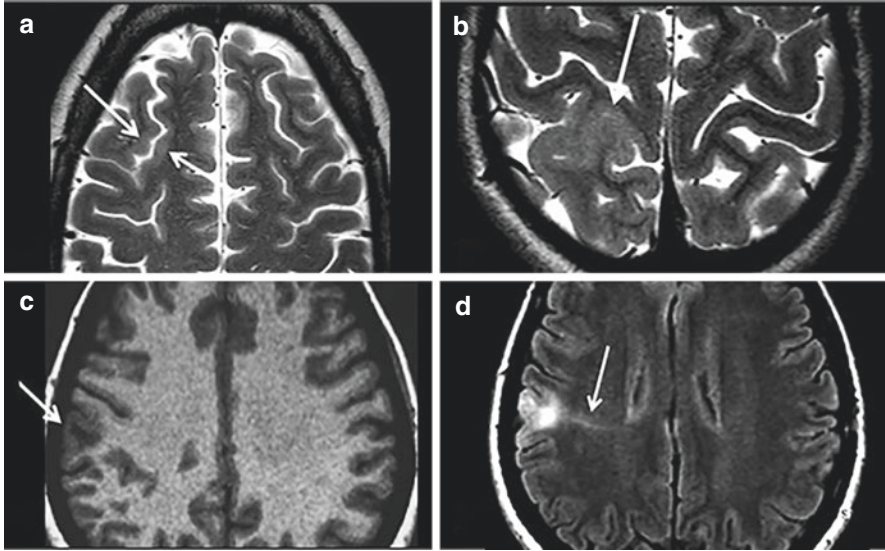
(a and b) axial high-resolution T2-weighted TSE axial imaging. (a) Arrow pointing areas of cortical thickening with isointense subcortical white matter, and (b) hyperintense white and grey matter without clear boundaries. (c) 3DT1 MPRAGE slice showing hypointense white matter with sharp demarcation of the cortex. (d) FCD type IIb with the transmantle sign is pointed out on an axial FLAIR slice
